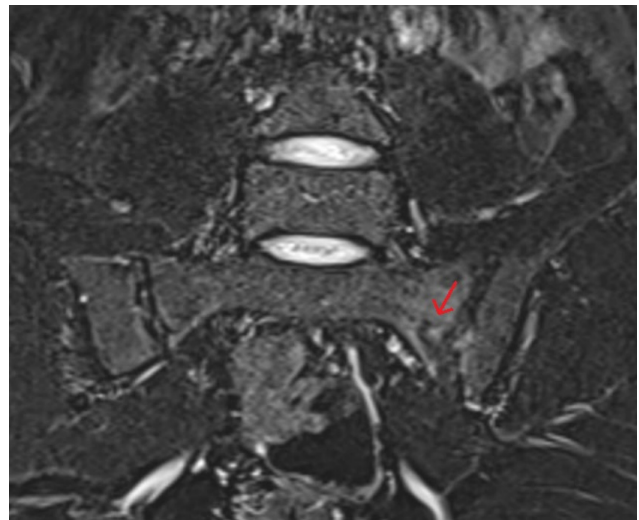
Sacroiliac magnetic resonance imaging (patient B). Retro-spective review of the sacrum reveals a sacral ala stress fracture pattern with marrow edema, despite an initially unremarkable report. The arrow indicates bone marrow edema in the sacral ala with a visible fracture line.
